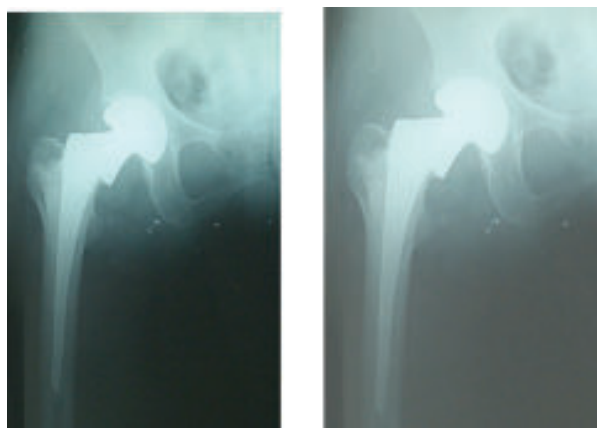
Postoperative X-ray (at 2nd POD), b. Post-operative X-ray (after 24 weeks)*
